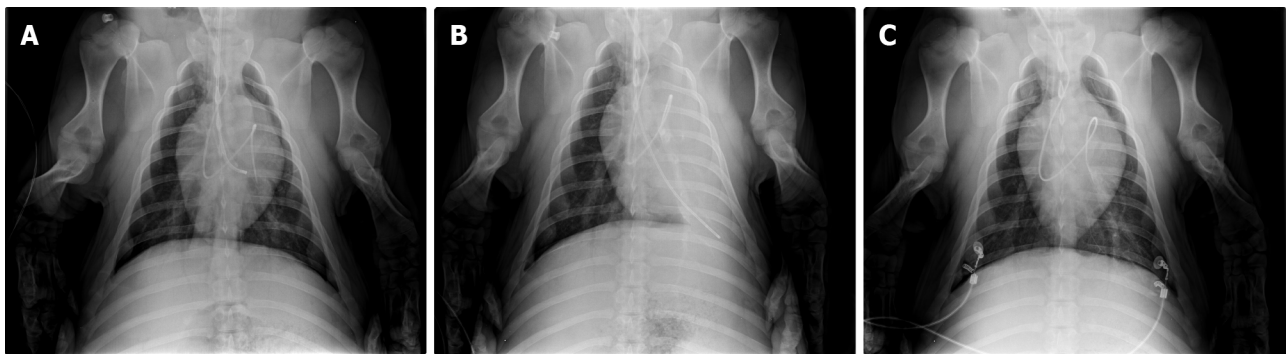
Chest X-ray. A: Before one-lung flooding. Correct position of the left-sided double-lumen endobronchial tube was confirmed using a fiber optic bronchoscope. Pulmonary artery catheter was placed in the left pulmonary artery; B: after one-lung flooding of the left lung wing. A pulmonary artery catheter placed in the left pulmonary artery. An endobronchial catheter placed in the left lower bronchus and inserted through the left lumen of the tube; C: 30 min after fluid drainage and conventional ventilation of both lungs. The X-ray shows normally aerated lung wings.
